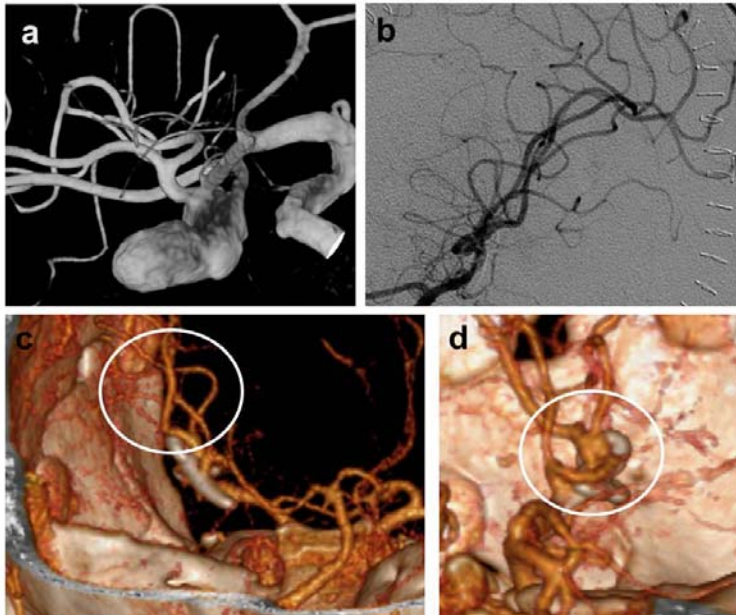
Complete trapping “variant” + flow-replacement IC-IC bypass. A complex unruptured MCA bifurcation aneurysms (partially thrombotic and calcified) (pre-op DSA in figure a) has been treated by aneurysm clipping with sacrifice of the frontal M2 branch, that was previously revascularized by means of intracranial-intracranial M3-M3 side-to-side anastomosis. Postoperative DSA and 3D-CTA showed aneurysm exclusion and patency of the anastomosis (figures b-d).
